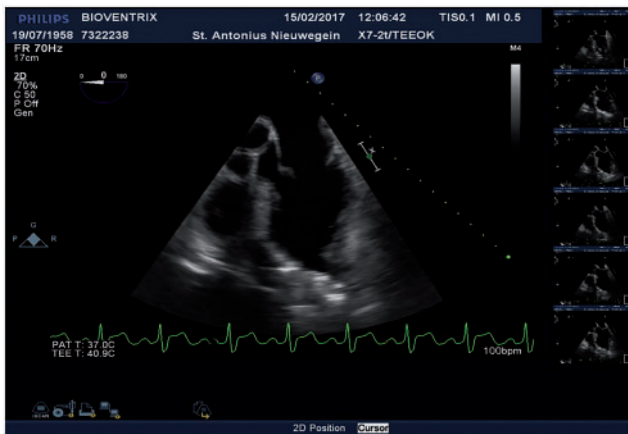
Intraprocedural transoesophageal echocardiography with completed reconstruction.
